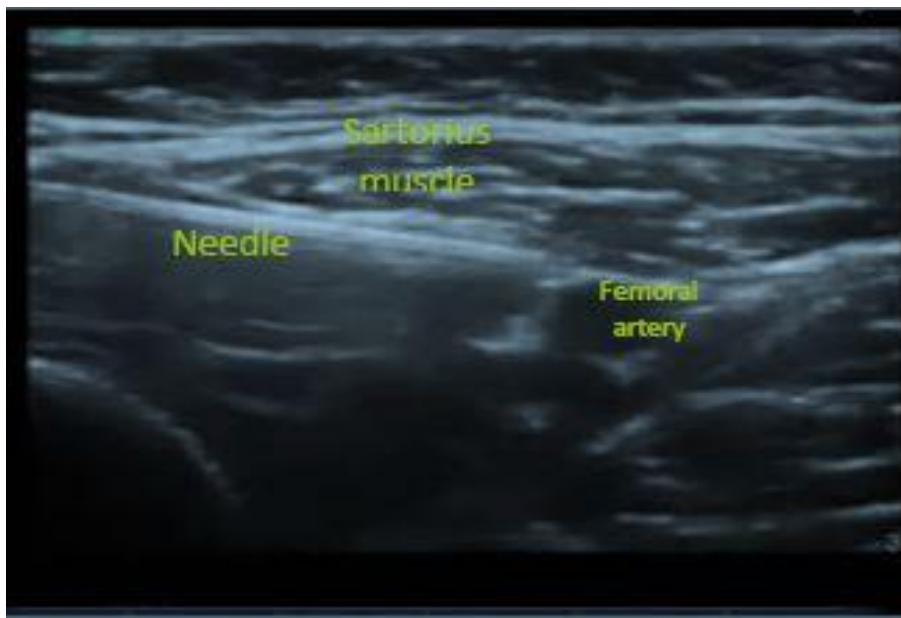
Ultrasound view of needle advancement towards the adductor canal
